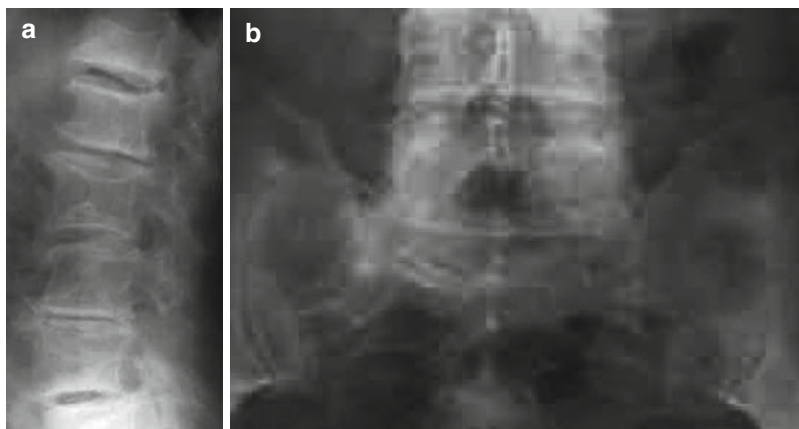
Radiograph of metabolic Charcot spondyloarthropathy. Female diabetic patient (58 years) with type 2 DM and MS with 12-year history and 6D syndrome of Charcot spondyloarthropathy. (a) LL view (b) AP view
